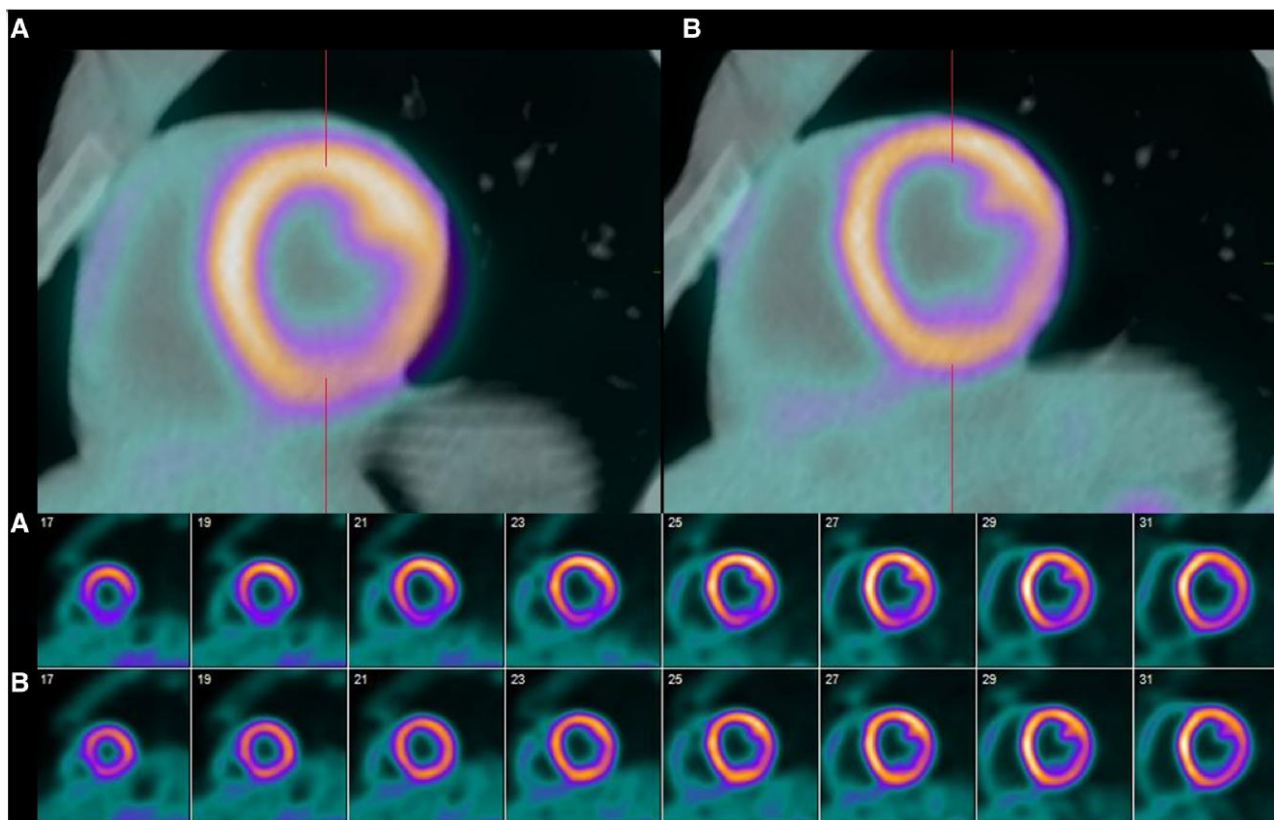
CT transmission-emission misalignment. Misalignment of CT transmission and $^{13}\text{N-NH}_3$ emission scan inferiorly and inferolateral causes an apparent perfusion defect (A) that disappears with proper alignment (B).
